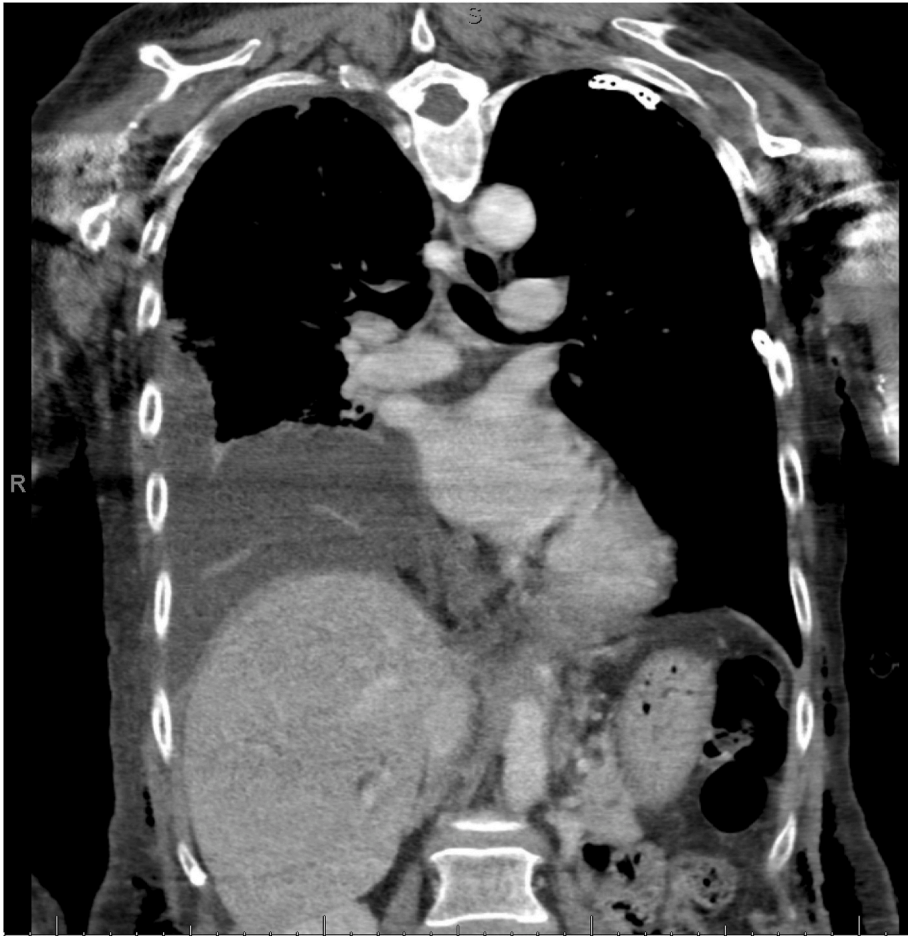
Day 8 CT Chest with IV contrast.
